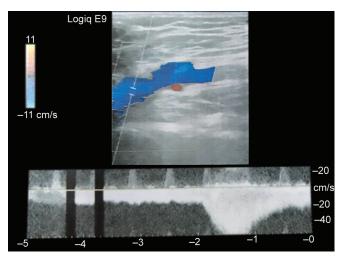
Doppler ultrasonogram of deep veins of leg and pelvis showing normal filling
